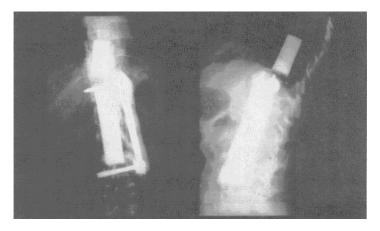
Radiograph of vertebral prosthesis, six years and six months postoperation.
